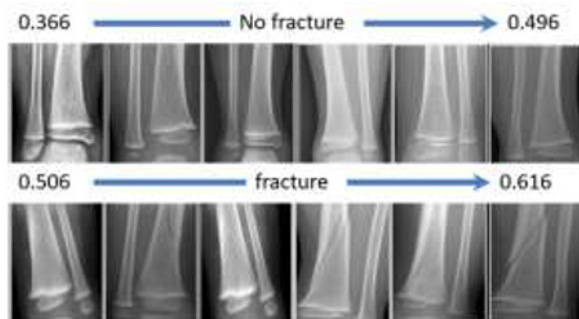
Representative radiographs with classification score. Top row: radiographs with no-fracture with score <0.5, bottom row: Radiographs with fracture with score ≥0.5
